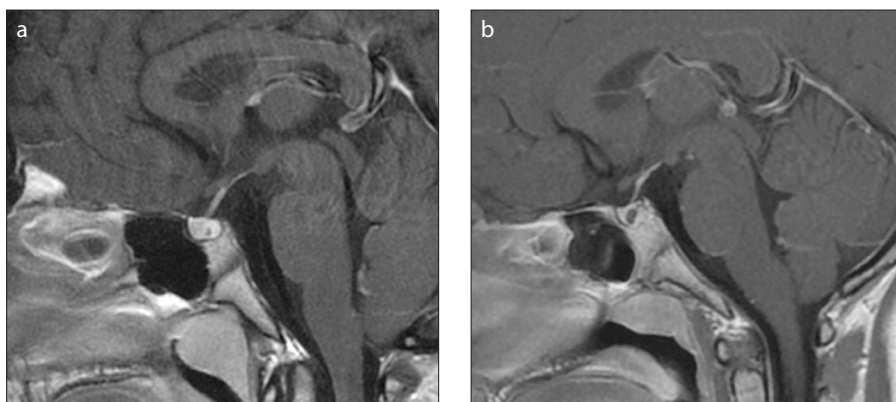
a, b. Sagittal contrast-enhanced T1-weighted images (a, b) demonstrate an RCC with increase in the anterior-posterior diameter and height on follow-up MRI.
